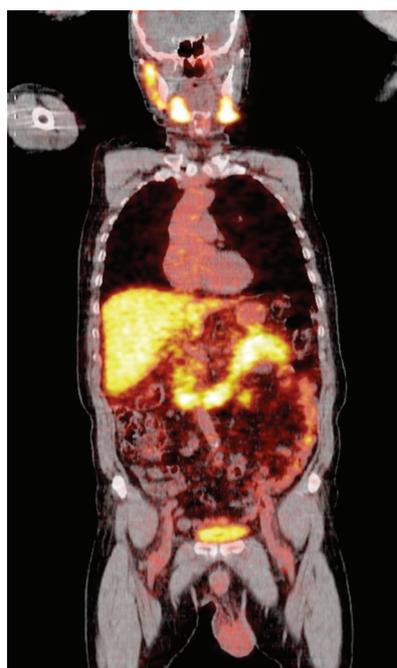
A patient with normal biodistribution of Ga-68 PSMA 1 h after injection. Accumulation is seen in the lachrymal and salivary glands, liver, spleen, bowel, kidneys and bladder
